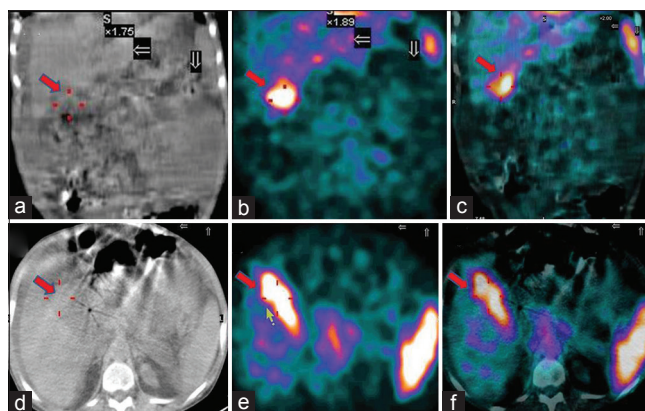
SPECT/CT images of the abdomen (coronal images [a: CT, b: SPECT, c: SPECT/CT fusion] and transaxial [d: CT, e: SPECT, f: SPECT/CT fusion]), acquired at 2 h to locate the site of tracer concentration (red arrow), revealed the tracer uptake at the gall bladder. SPECT/CT: Single-photon emission computed tomography/computed tomography
